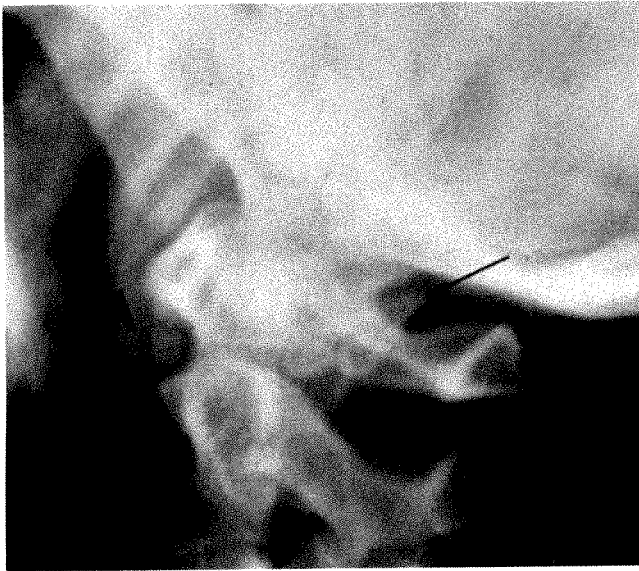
Lateral radiograph demonstrating ossicle (*large arrow*) below anterior arch of C1. Note incomplete development of posterior atlantal arch on one side (*small arrow*).
